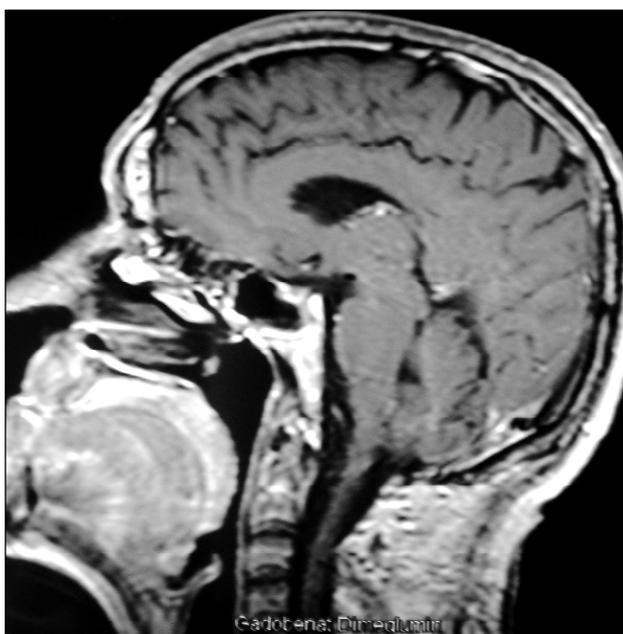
Postoperative T1 sagittal magnetic resonance imaging with gadolinium enhancement showing total removal of the foramen magnum tumor.
